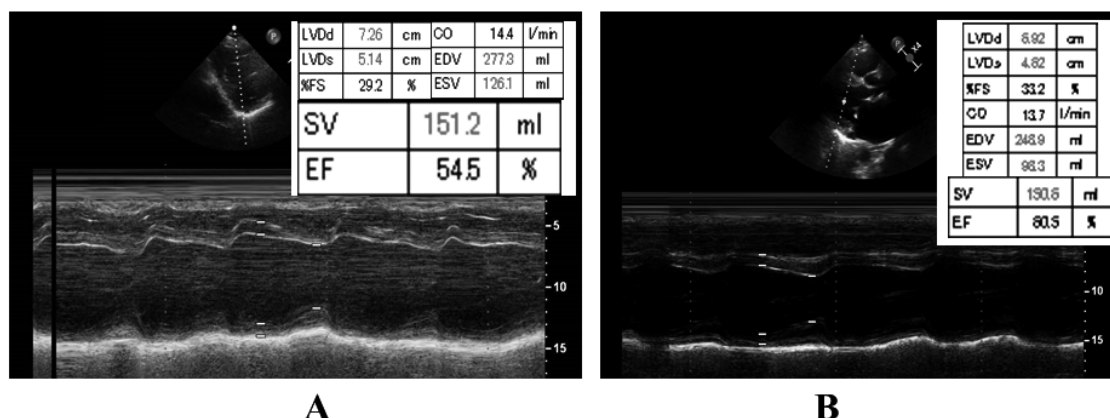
Transthoracic echocardiography at discharge (A) compared with one year after initiation of ipragliflozin (B). Cardiac size was slightly smaller after one year. Ejection fraction was preserved.
